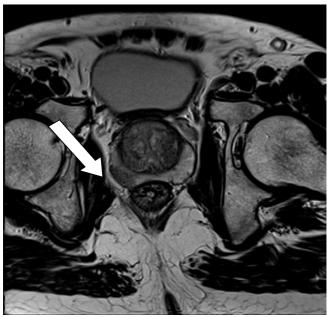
T2-weighted image showing hypointense nodular area in the prostate peripheral zone in the middle third to the right (arrow).
